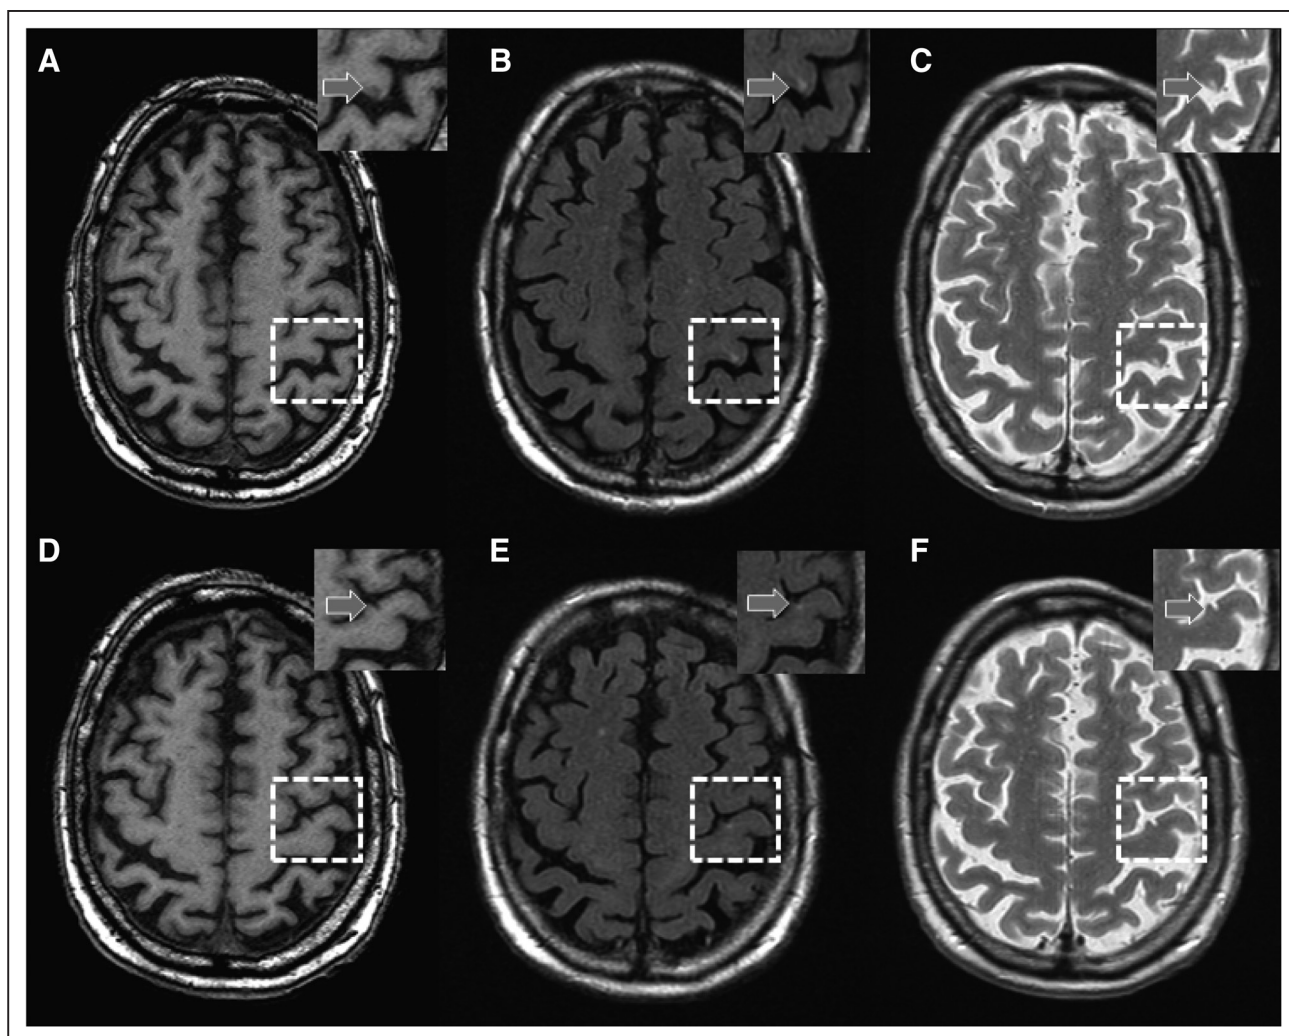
Example of cortical cerebral microinfarct (CMI) on 1.5T magnetic resonance imaging (MRI).
